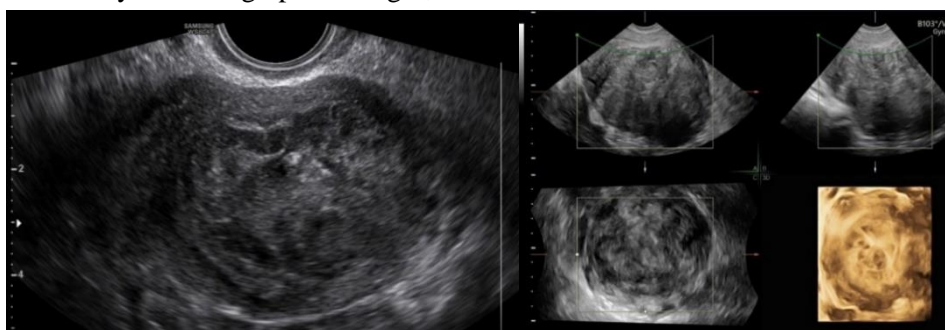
Transvaginal ultrasound image showing a tumor diagnosed finally as STUMP on gray-scale (A) and 3D imaging (B)
